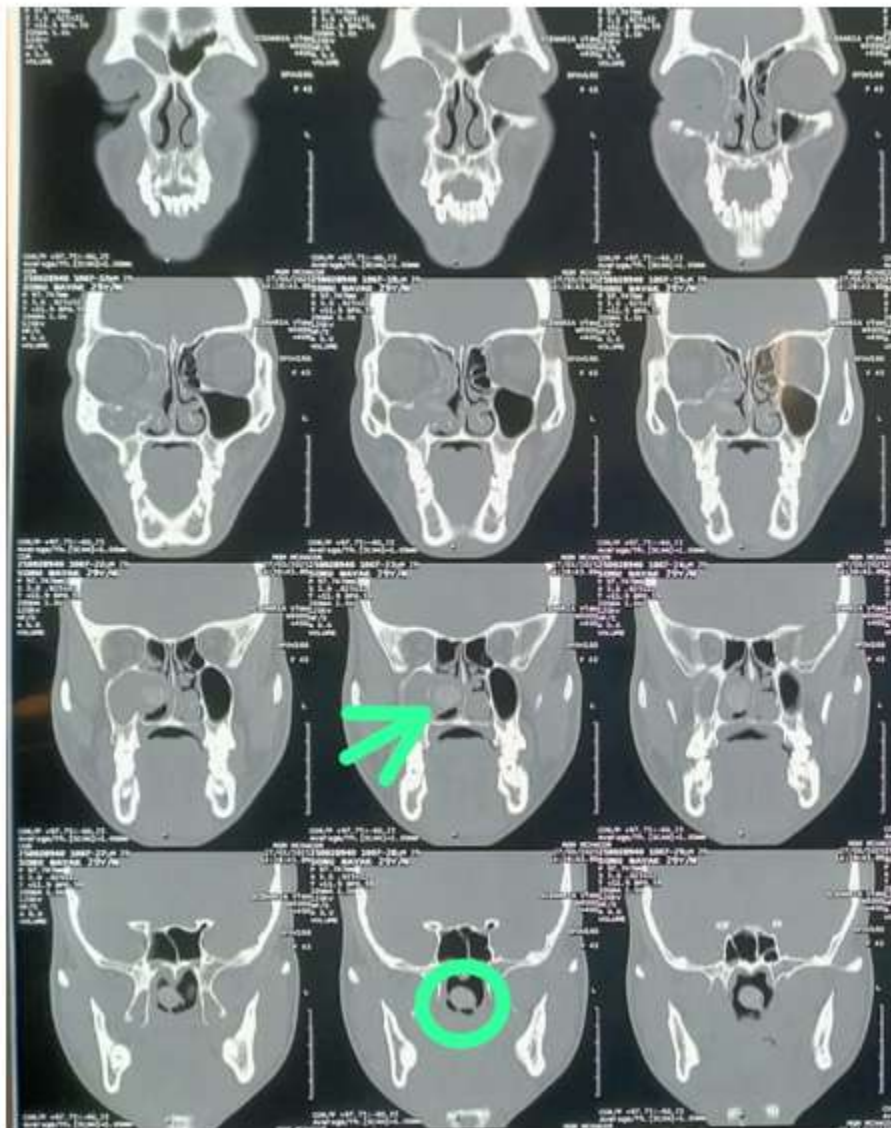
(arrow) CT Face image showing hyperdense tubular structure in right nasal cavity and right maxillary sinus
